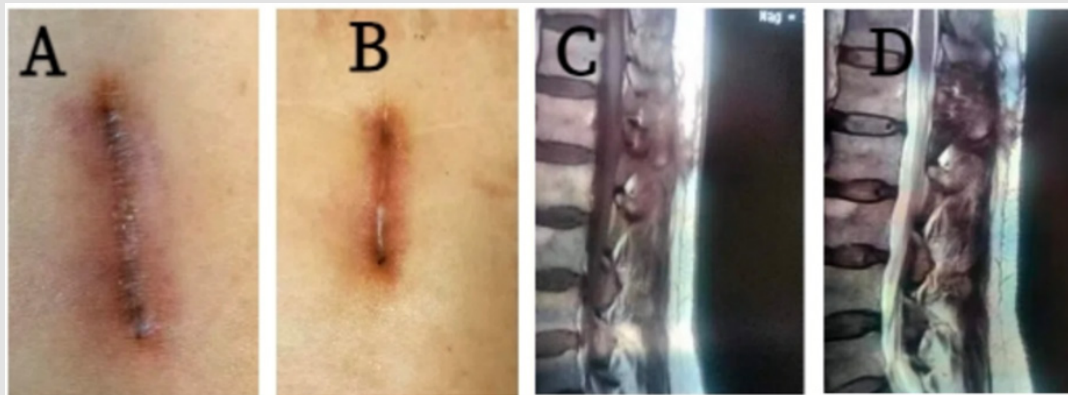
Radiographic images.
